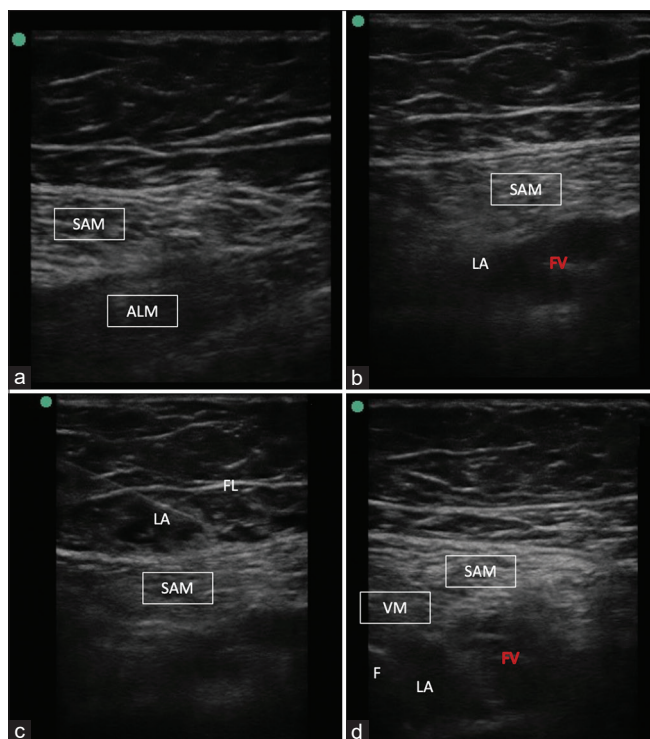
TIPS block. (a) Ultrasound-guided determination of the apex of the femoral triangle where the medial border of SAM meets the medial border of ALM. (b) The probe was slid cephalad 2 cm above the apex of the femoral triangle. The needle was advanced from lateral to medial, and LA was injected under SAM lateral to femoral vessels (c) The needle was withdrawn subcutaneously and advanced superficial to SAM underneath FL, and LA was injected. (d) The probe was slid distally along SAM until femoral vessels slipped posteriorly to reach the popliteal fossa. LA was injected posterior to femoral vessels. ALM = adductor longus muscle, F = femur, FL = fascia lata, FV = femoral vessels, LA = local anaesthetic, SAM = sartorius muscle, TIPS = triple injection peri-sartorius, VM = vastus medialis
